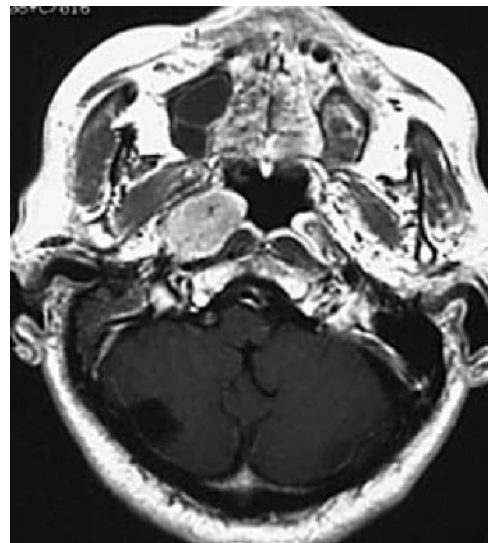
A 64-year-old man presenting with Type 2a (unilateral invasive type) spread. Axial T_1 weighted MR image, Gd-DTPA enhanced, shows a right nasopharyngeal tumour infiltrating the right parapharyngeal space.
